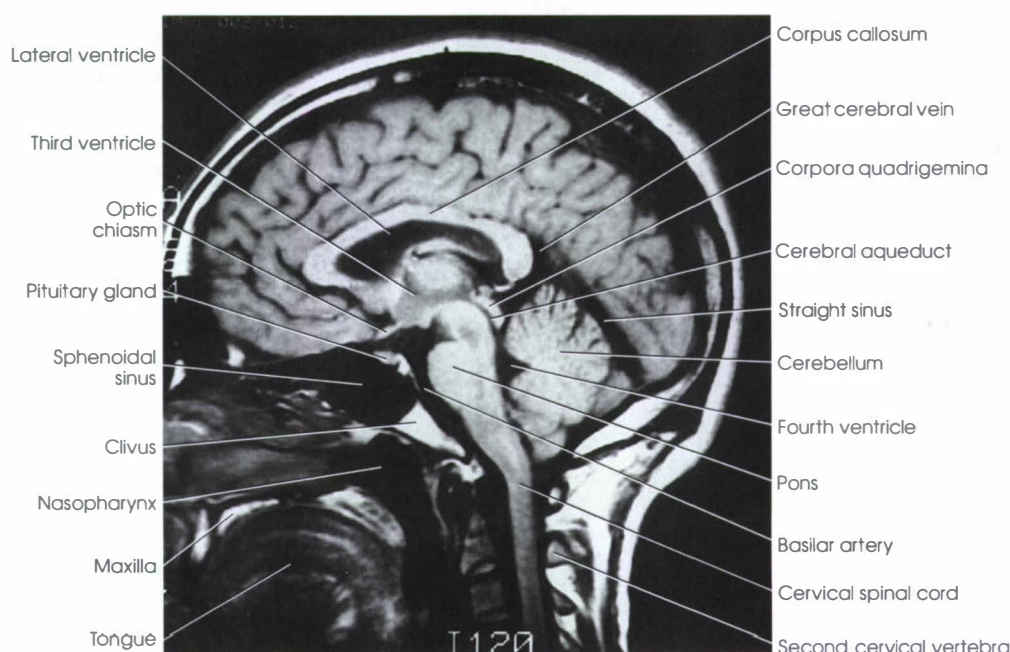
MRI through midsagittal plane.
